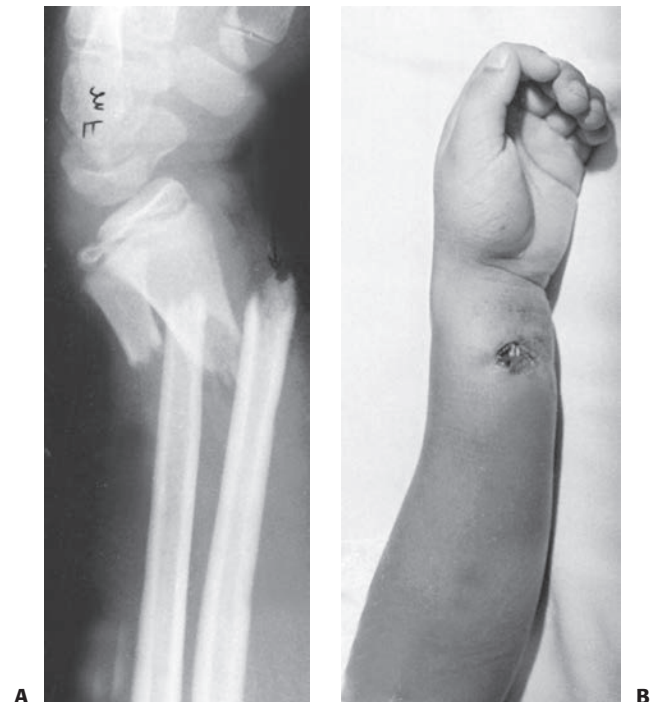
Open fractures. Radiograph (A) and clinical photo (B) of an open fracture of the distal radius. This patient needs formal irrigation and debridement in the operating room.
